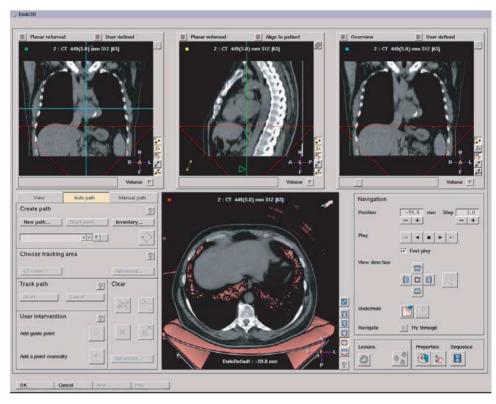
Modern CT workstations offer views of a variety of multiplanar reformats simultaneously, allowing for easier navigation and three-dimensional visualization by the radiologist.
